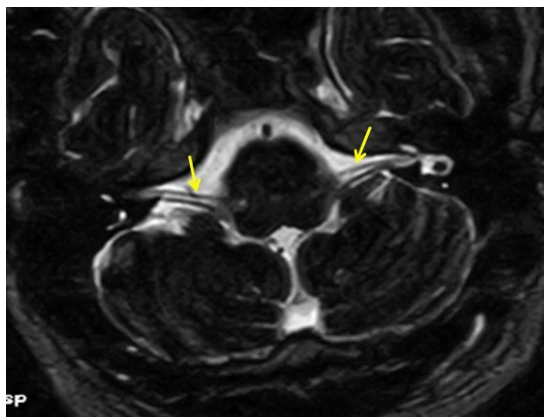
MRI aspect, axial sequence 3DT2 showing a normal nerve VII (yellow arrow).
